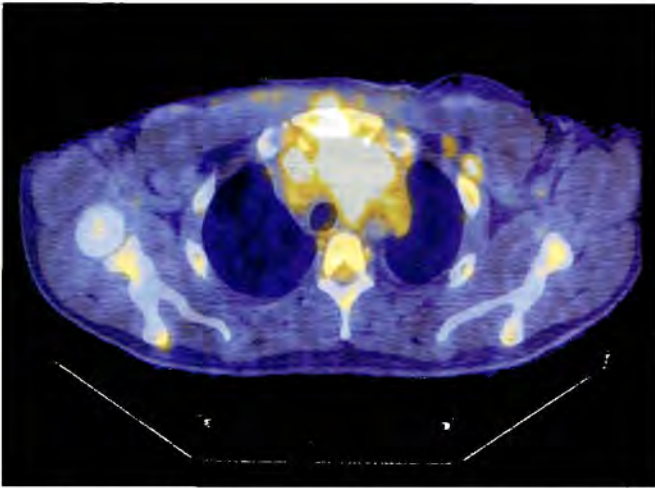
Additional sites of patchy bone marrow involvement were identified within the scapulae and axial skeleton. No observable CT correlate was seen for these lesions.
